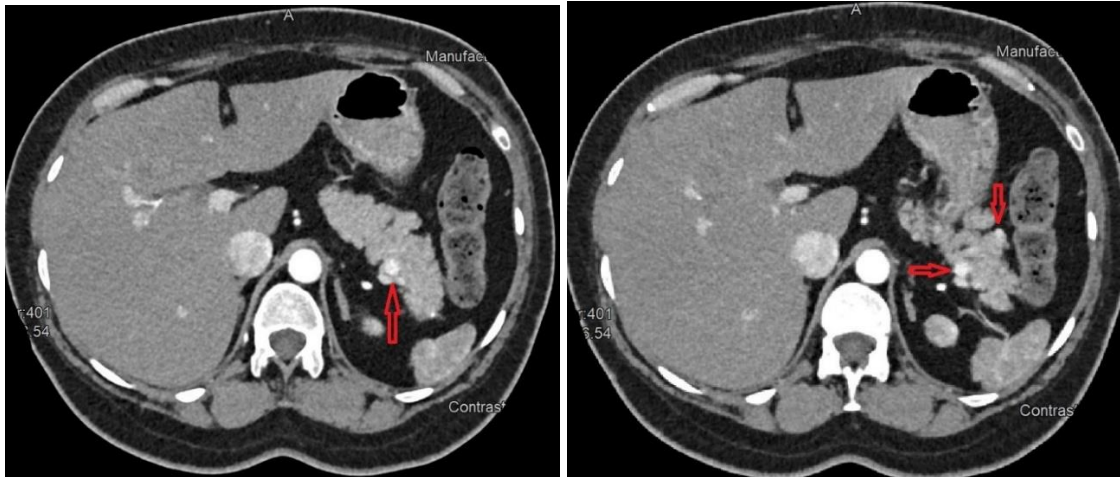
Contrast-enhanced CT scan of the abdomen and pelvis with red arrow indicating the location of pancreatic lesions.
